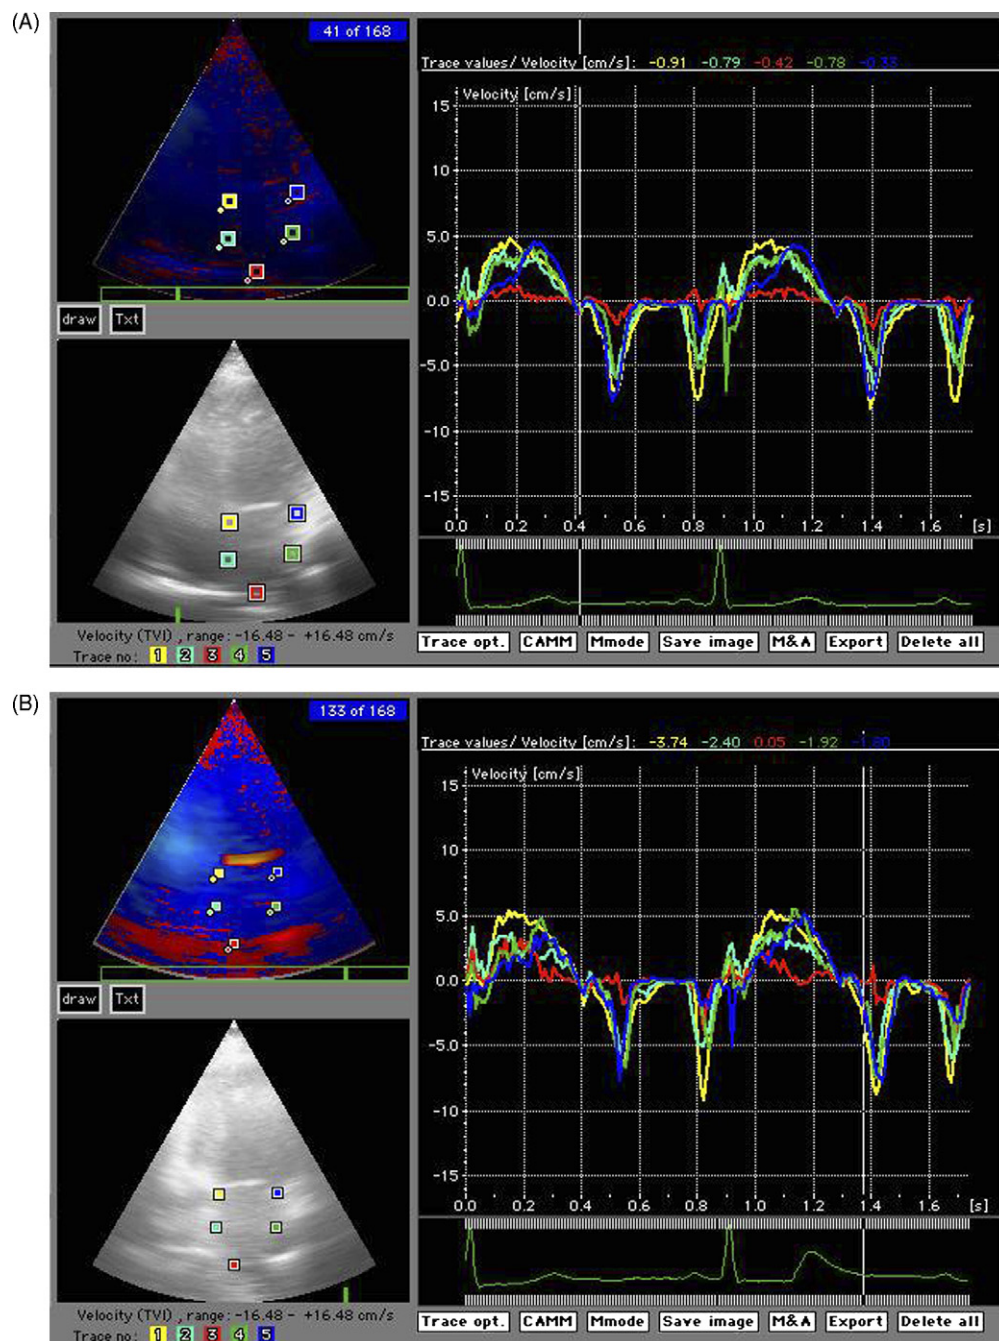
Segmental longitudinal atrial contraction from the apical four- and two-chamber views. (A) Apical four-chamber view measuring segmental LA velocities. (B) Apical two-chamber view measuring segmental LA velocities.
